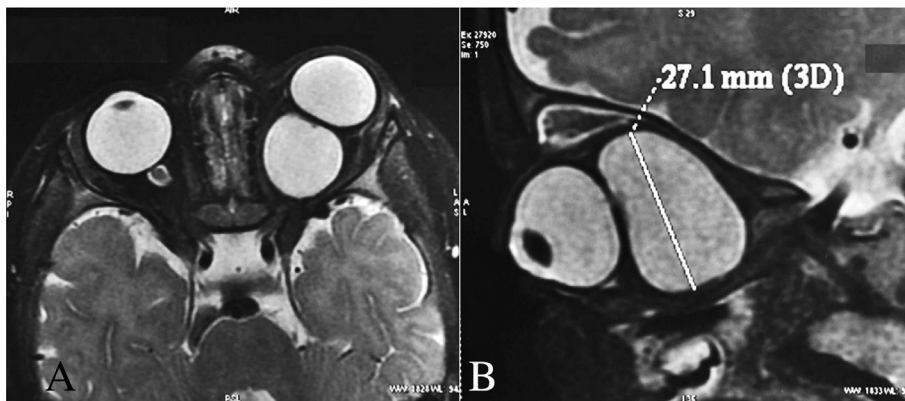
MRI images showing a well-defined, intraconal, hyperintense in T2 weighted images (isointense to vitreous), cystic lesion in close relation to the posterior surface of the globe displacing the optic nerve laterally. (A – parasagittal slice. B – coronal slice).
